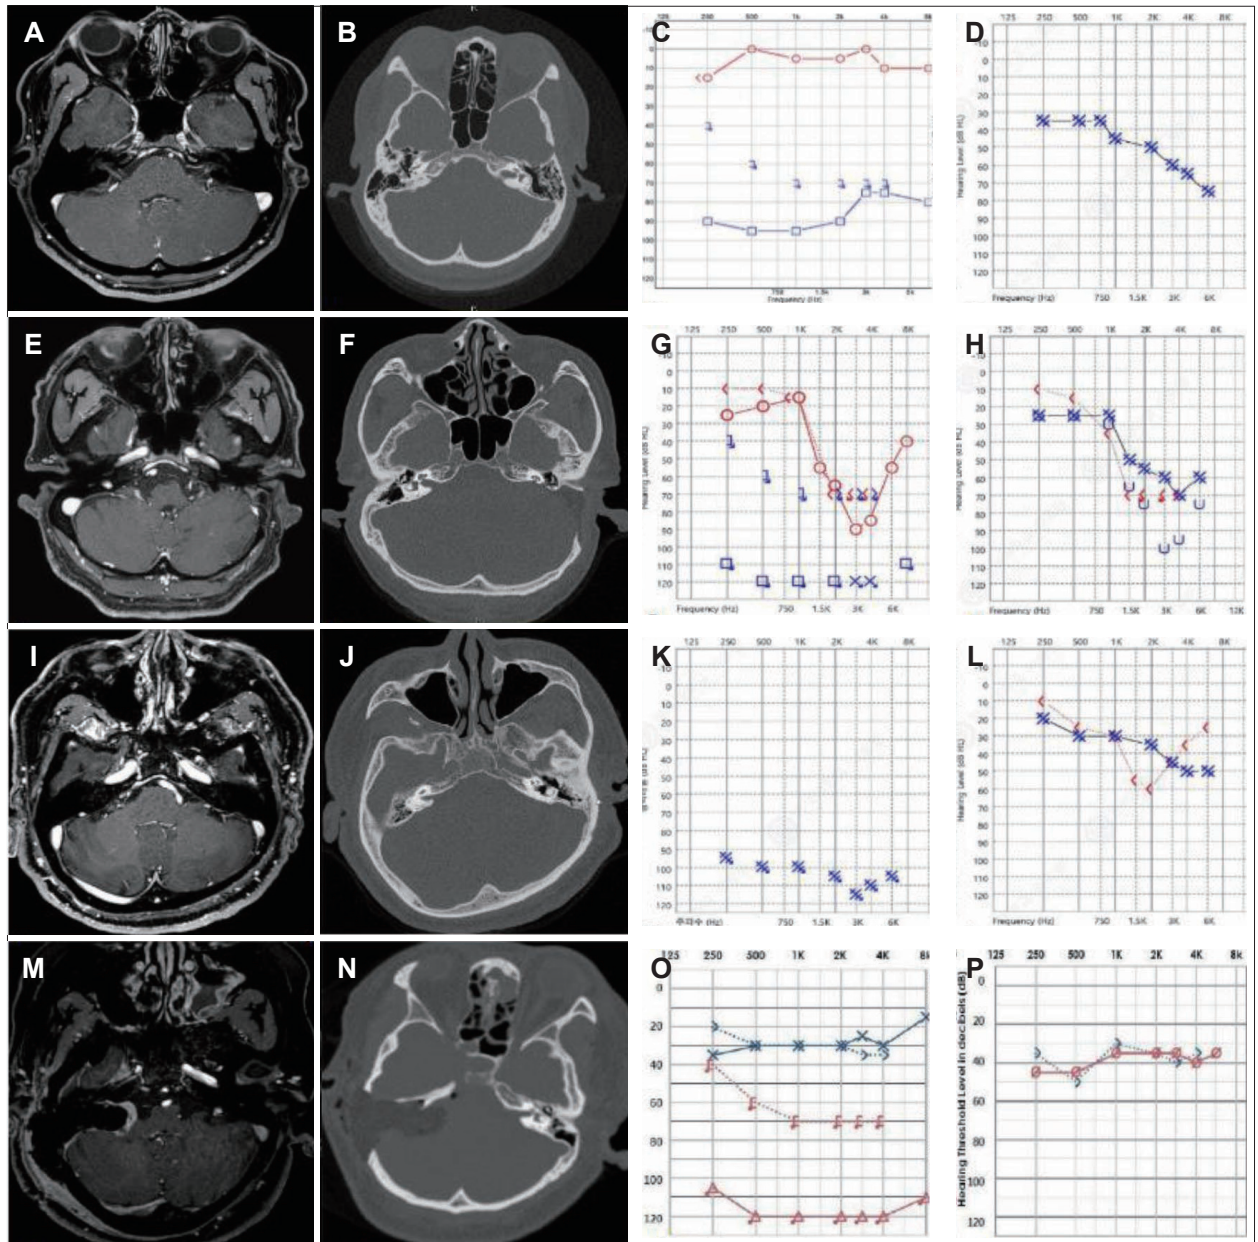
Patients description. Figures showed pre implantation (and post VS removal images), preimplantation and post-implantation PTA of the patient who received BAHA attract after mEETTA and (A-D), of the patient who received BAHA attract after TLA (E-H), of the patient who received Bonebridge after MCFA (I-L), and of the patient Sophono after TLA. Above images are for each patient's preoperative and postoperative findings. Each line left side 2 pictures (A, B, E, F, I, J, M, N) are temporal MRI and temporal bone CT which were taken right before BCIs surgeries, and right side 2 pictures (C, D, G, H, K, L, O, P) are preoperative/postoperative BCIs surgeries' pure tone audiograms. VS, vestibular schwannoma; PTA, pure tone audiogram; BAHA, bone anchoring hearing aid; mEETTA, modified exclusive endoscopic transcranial transpromontory approach; MCFA, middle-cranial fossa approach; TLA, translabyrinthine approach; BCI, bone conduction implant.
